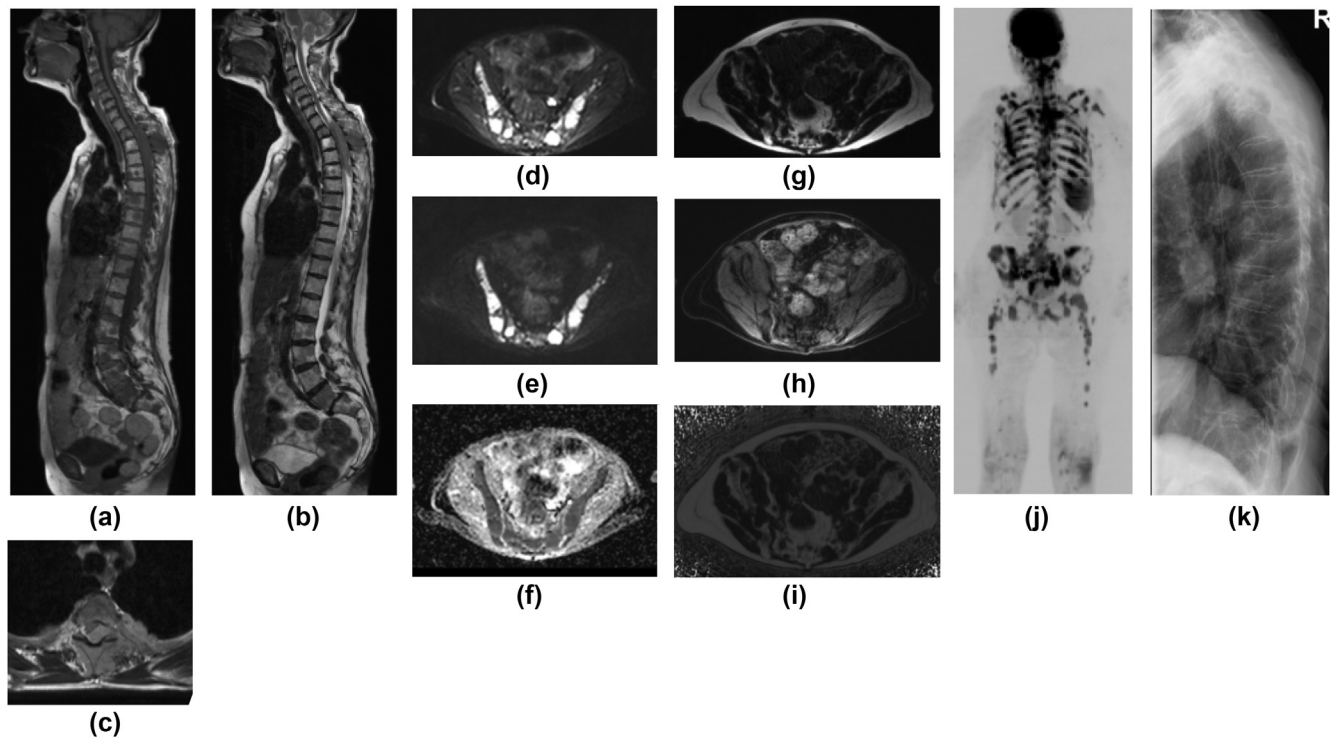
Core MY-RADS protocol in a patient with multifocal myeloma bone disease. (a) Sagittal T1W and (b) T2W images. (c) Supplemental axial T2W images; (d) axial $b = 50 \text{ s/mm}^2$ DW-MRI; (e) $b = 900 \text{ s/mm}^2$ and (f) ADC map from DW-MRI acquisition. (g) Axial fat-only (h) water-only and (i) FF map from Dixon MRI. (j) Inverted grey-scale $b = 900 \text{ s/mm}^2$ MIP. Despite the large burden of multifocal disease and cord compression in (a-c), the skeletal survey was reported as negative for focal bone disease (k, lateral thoracic spine radiography).
